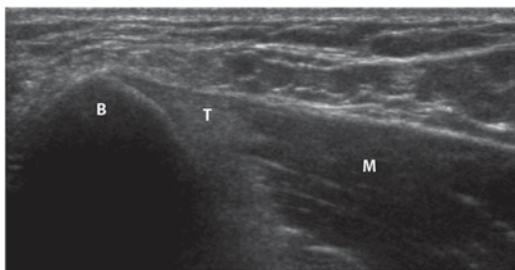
Longitudinal ultrasound view of the medial elbow showing the medial epicondyle of the humerus (*B*), the common flexor-pronator tendon (*T*), and the flexor-pronator muscle (*M*)
